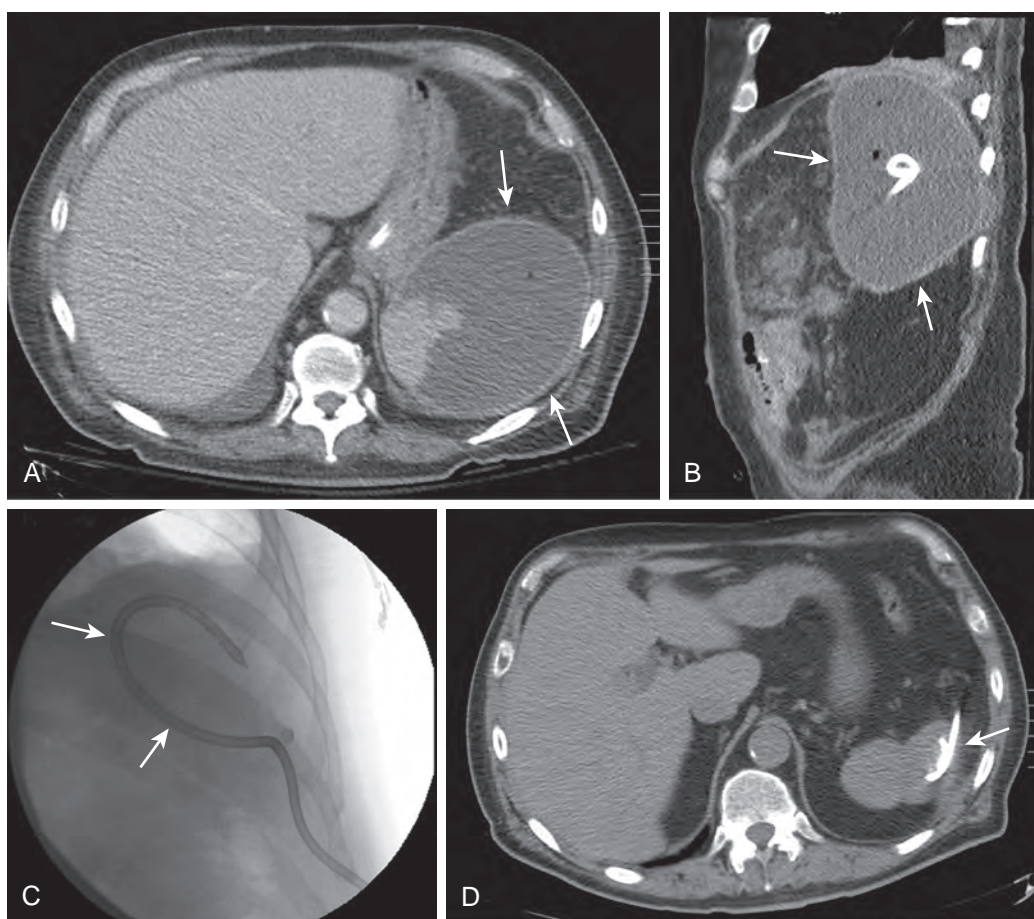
Improved drainage of a perisplenic abscess after catheter exchange for a larger catheter with more side holes. A. Axial contrast-enhanced CT image in a 54-year-old man shows a large perisplenic abscess (arrows). B. Sagittal CT image shows persistent abscess despite adequate positioning of the catheter (arrows). C. Fluoroscopic image shows placement of a larger bore catheter with more side holes into the abscess over a guidewire (arrows). D. CT obtained 2 weeks later showed complete resolution of the abscess (arrow).
